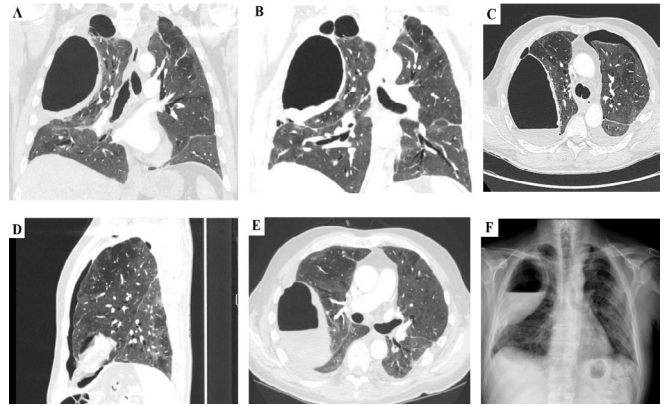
(A,B) – A coronal chest CT scans demonstrating a complex structure of right-sided lung cyst (C) – An axial and (D) – sagittal chest CT scan showing left-sided pneumothorax (E) – An axial chest CT scan presenting air-fluid level in the lung cyst (F) – A chest X-ray showing thickening of the cyst wall and fluid level
